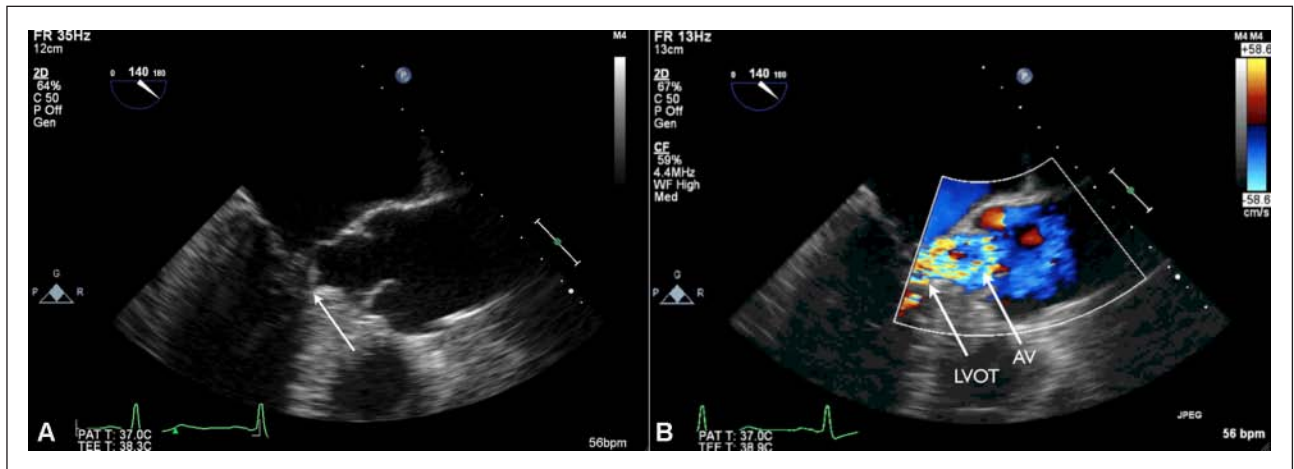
Transesophageal echocardiography aortic valve long-axis view
